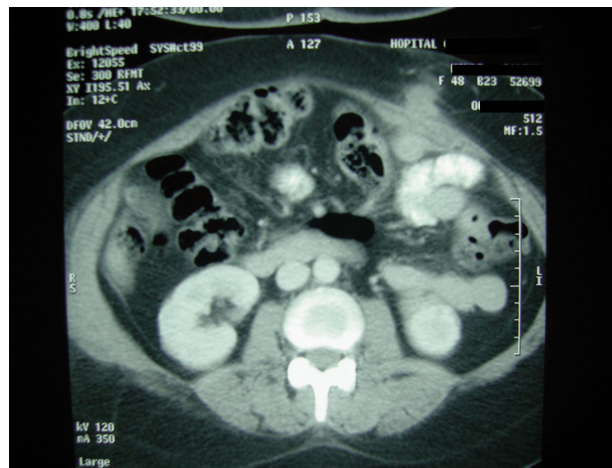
Abdominal CT scan: intra-peritoneal tissue- structure linked to the parietal peritoneum at the left hypochondria.
